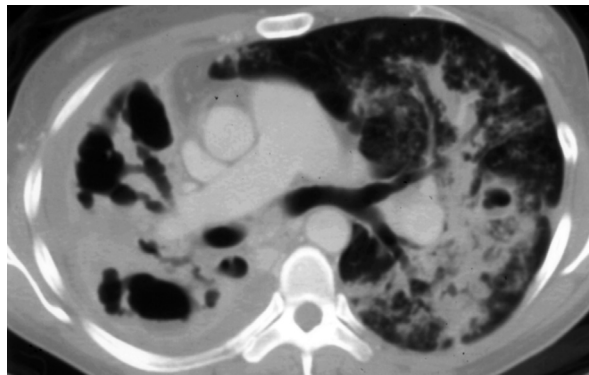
Computed tomography of the chest depicts peribronchial consolidations at the left upper lung and right-side destroyed lung with cavities and bronchiectasis.
